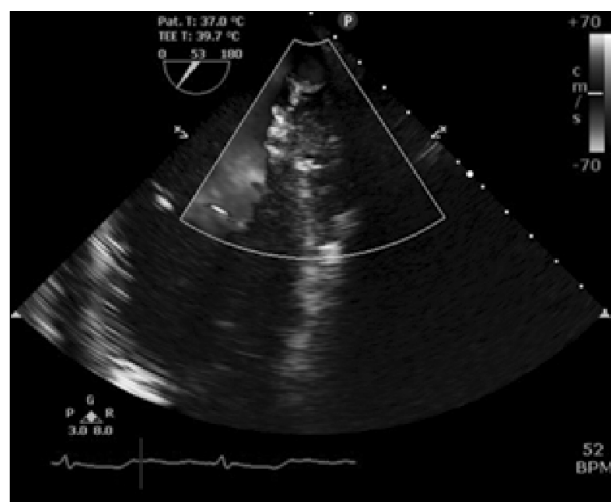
Transesophageal echocardiography image obtained after CPB showing no thrombus in the LA and ligated LAA. CPB: cardiopulmonary bypass, LA: left atrium, LAA: left atrial appendage.
